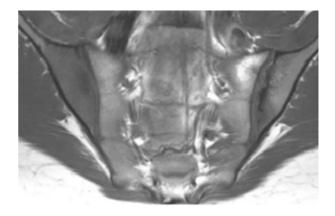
MRI oblique coronal fat-sensitive T1SE and fluid-sensitive T2-weighted fat-saturated sequence – early right sacroiliitis with contrast enhancement of the joint and abnormal bone marrow in post-gadolinium sequence without soft tissue signal changes or localised.
